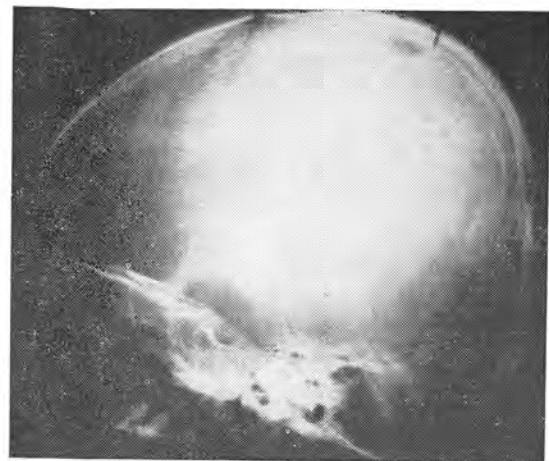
X-ray photos of the skull presenting the osteolytic areas within the parietal and frontal bones.
